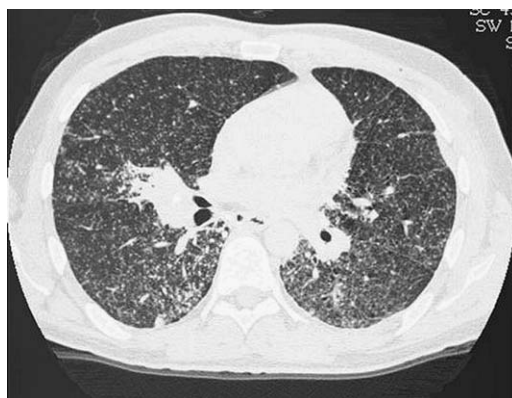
CT scan of miliary histoplasmosis.
